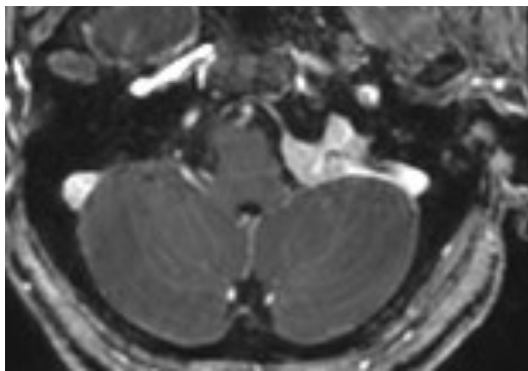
Lymphoma causing hypoglossal denervation. Axial-enhanced T1-weighted image shows a broad-based dural lesion overlying and extending into the left hypoglossal canal. This could be easily mistaken for a meningioma.
